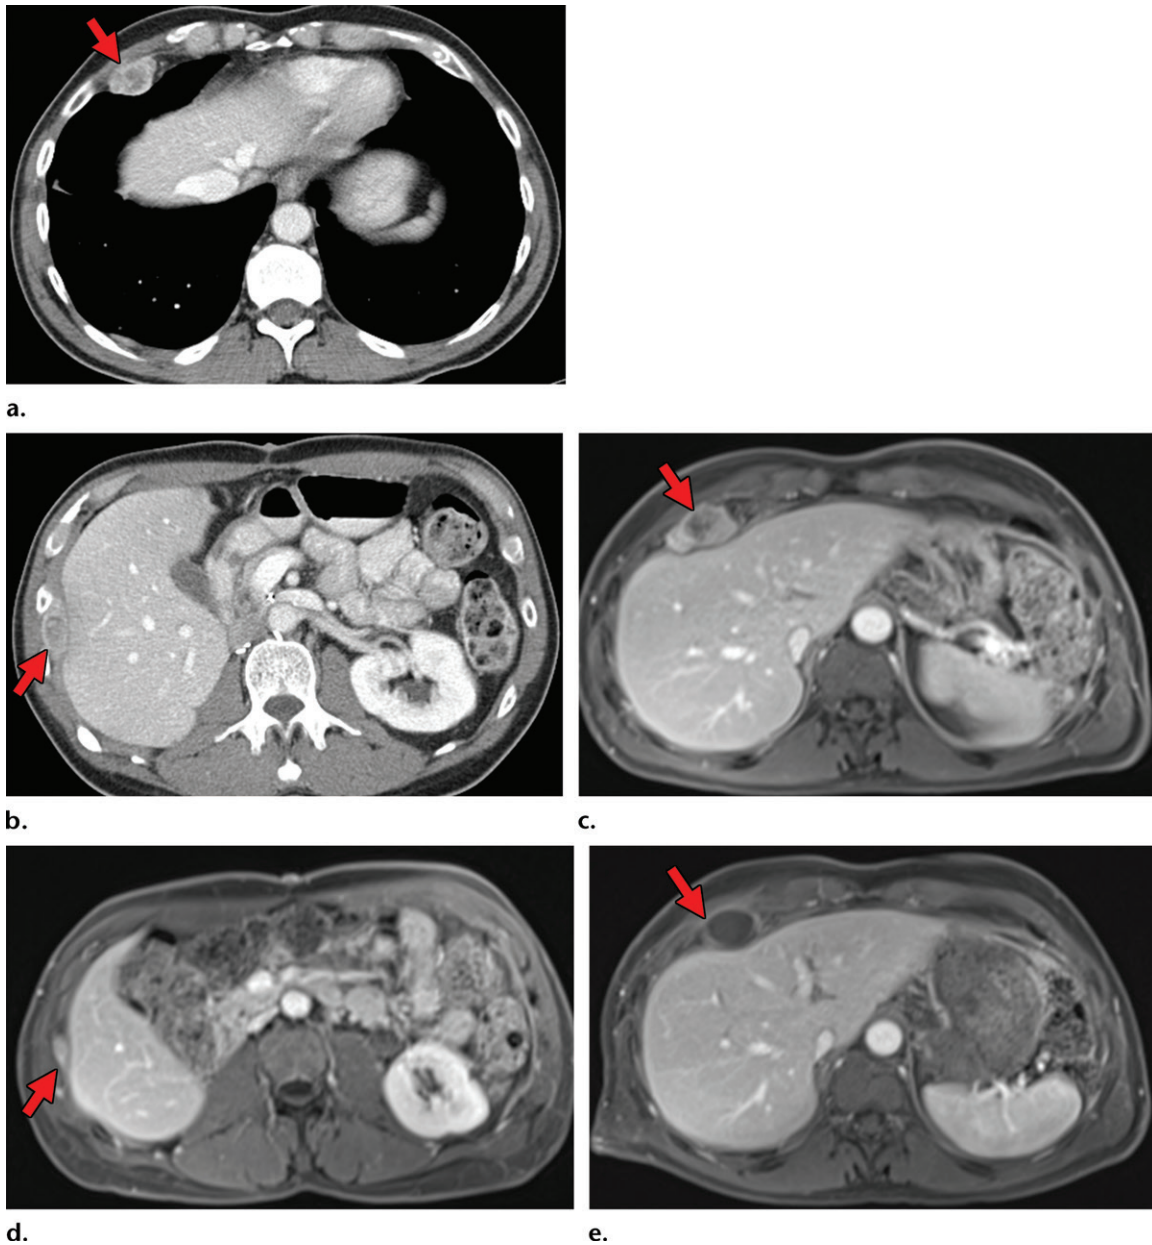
Metastatic clear cell RCC in a 53-year-old man undergoing therapy with nivolumab with oligoprogression. (a, b) Axial contrast-enhanced CT images through the lower chest and upper abdomen before the initiation of nivolumab show several extrapleural metastases in the right hemithorax (arrow). The patient subsequently received nivolumab. (c, d) Axial contrast-enhanced MR images acquired 6 months after therapy show that most of the lesions decreased in size substantially (arrow in d), but one of the metastases had enlarged (arrow in c). Another extrapleural metastasis had resolved (not shown). (e) Axial contrast-enhanced MR image from an examination after radiation therapy was performed for the enlarging lesion shows a decrease in size and enhancement of the right chest wall lesion (arrow). The patient continued to take nivolumab for an additional 6 months.
